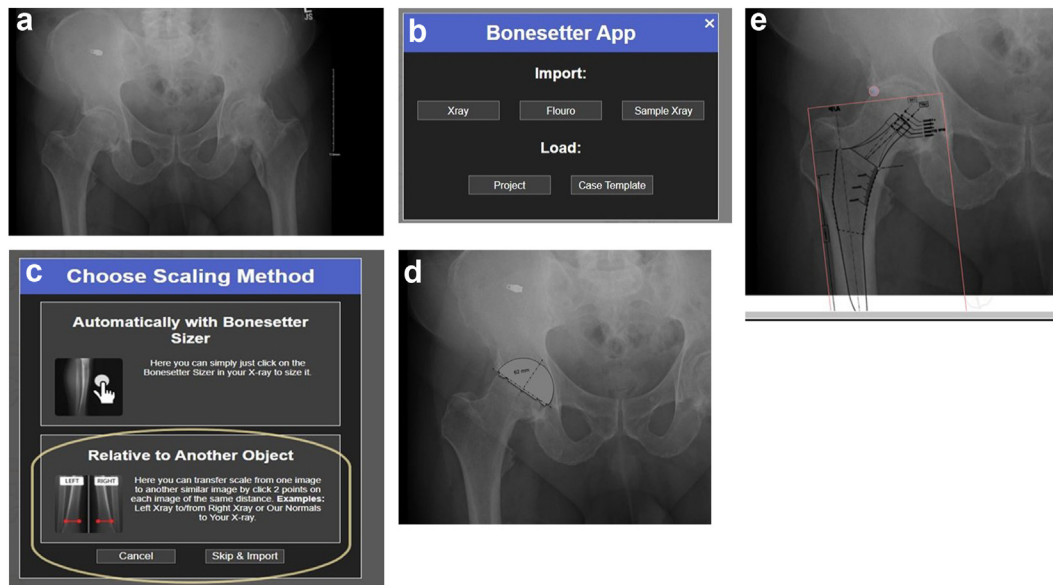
Steps to templating using Detroit Bone Setter. (a) Choose best available X-rays with digital marker, use snipping tool to take a picture. (b) Import X-ray picture into bonesetter. (c) Autoscaling with metal marker or manual scale using digital marker (vertical ruler). (d) Template for acetabular cup. (e) Template for femoral stem.
